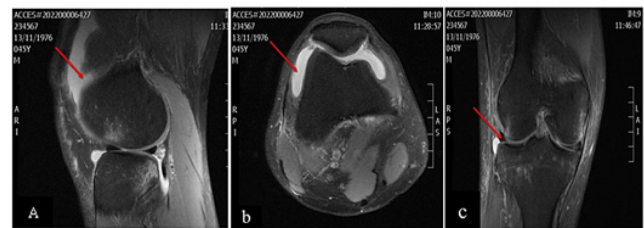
MRI images of the knee for a 45-year-old male who presented with pain and swelling in his left knee after a twisting injury:
